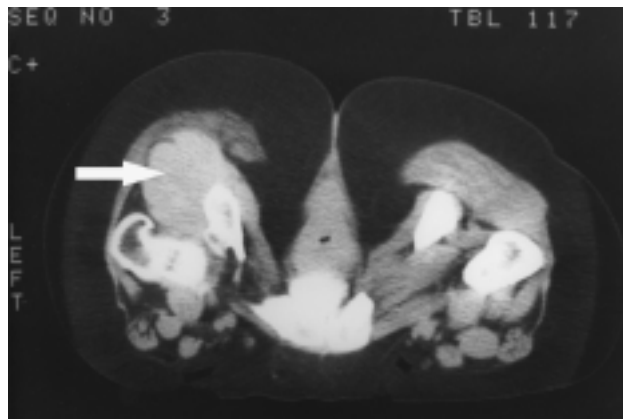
Computed tomographic scan of the patient taken at age 33 years showing desmoid tumour (arrow) posterior to left hip extending around ischium.
